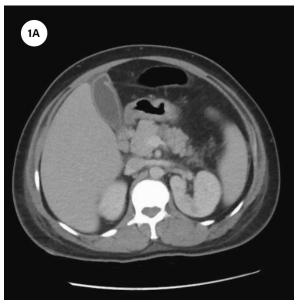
& 1B). CT Abdomen Axial (Left) and Coronal (Right) View, Liver Appears Enlarged and Spleen Appears Bulky.
